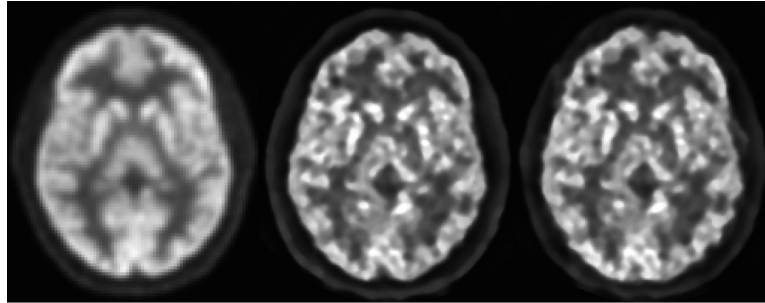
Example of a reconstructed image of a patient acquired on both scanners. Image acquired on PET/CT (left), on CMB reconstructed with emission-based attenuation map (middle) and on CMB reconstructed with CT-based attenuation map (right). From “*Objective image quality comparison between brain-dedicated PET and PET/CT scanners.*” by Maria Teresa Gandia-Ferrero, Irene Torres-Espallardo et al. 2023. Copyright by Journal of Medical Systems.
